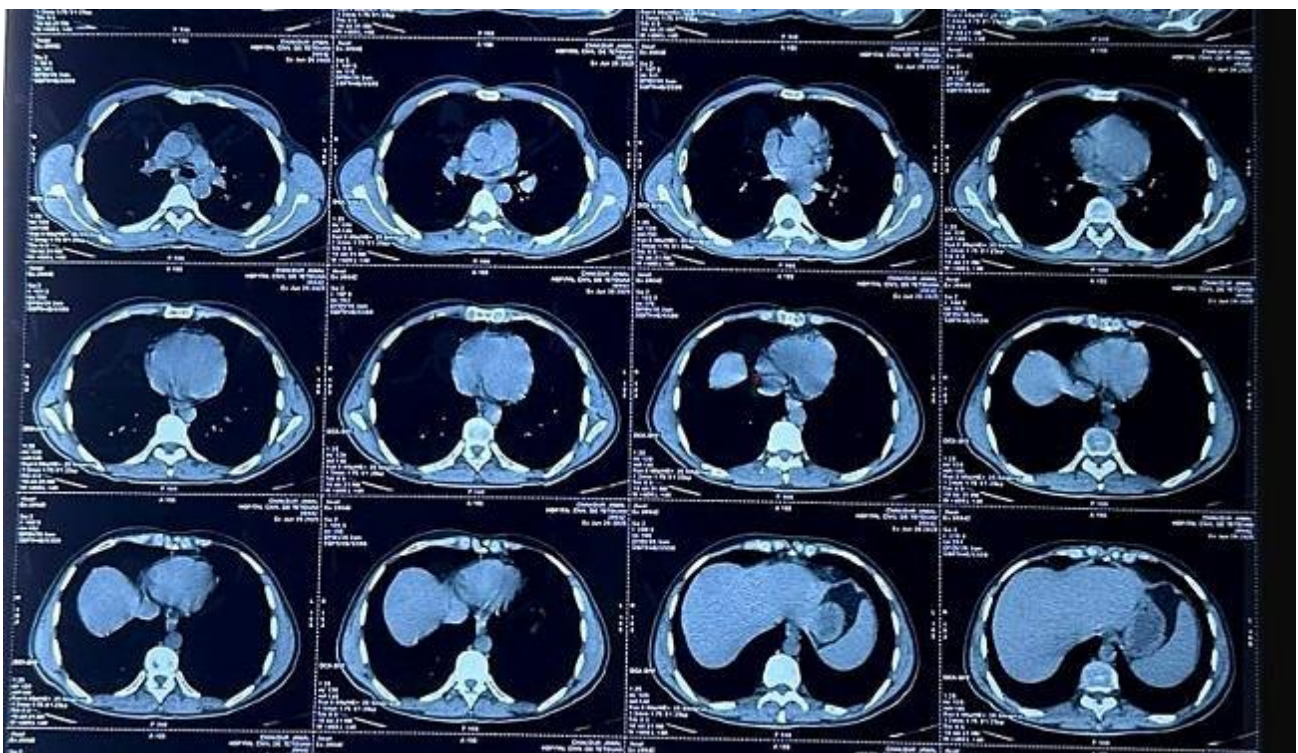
Chest CT scan, axial mediastinal window, at the level of the great vessels and hila, corresponding to the region where a few small (subcentimeter) prevascular, paratracheal, and aortopulmonary window lymph nodes were reported.
